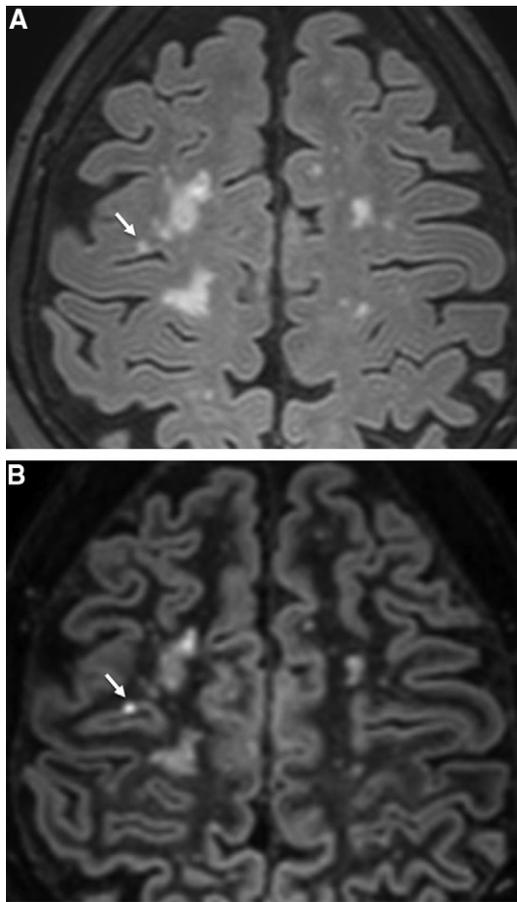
A 79-year-old woman with dementia deriving from Alzheimer's disease examined using 3D FLAIR and 3D DIR imaging. (A) 3D FLAIR and (B) 3D DIR images of a CMI in the right frontal lobe (arrows A and B). The CMI is more easily detectable with 3D DIR imaging (arrow B) than with 3D FLAIR imaging (arrow A).
